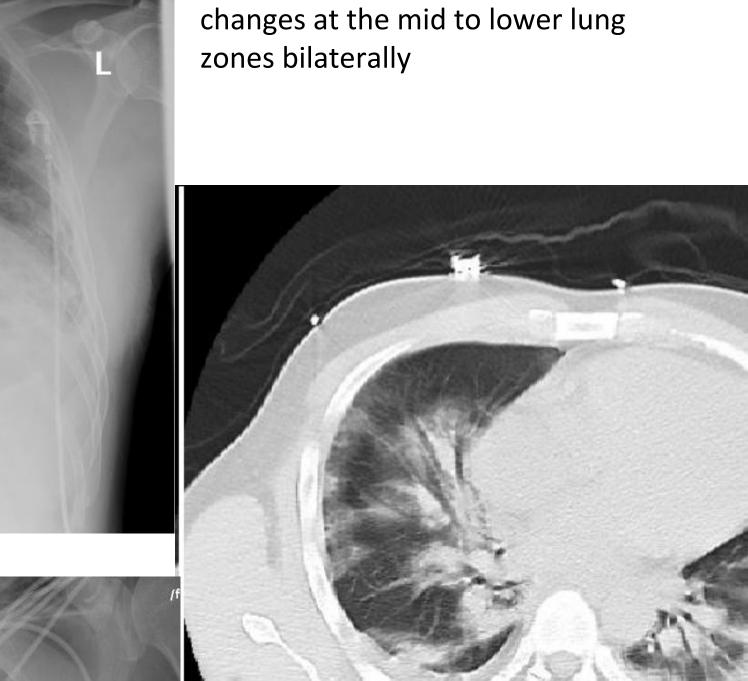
X-ray at presentation showing Interstitial
